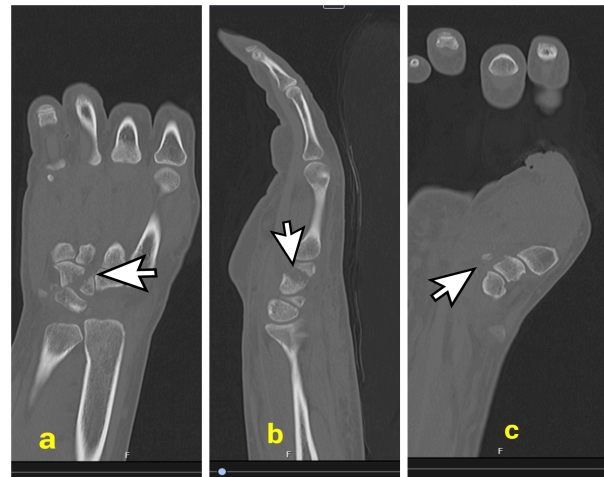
Pre-operative Computer Tomography (CT) cross-section images: a. Coronal Section b. Sagittal Section c. Trapezoidal Bone Fracture
